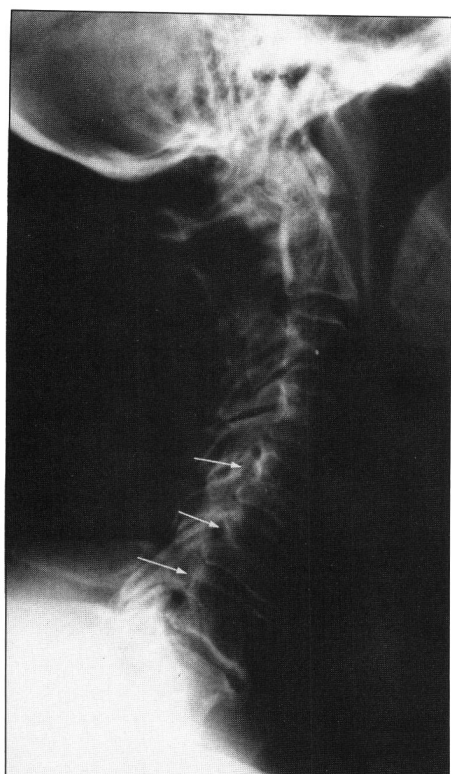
Lateral Cervical X-ray. Irregular longitudinal retrovertebral opacity.*
